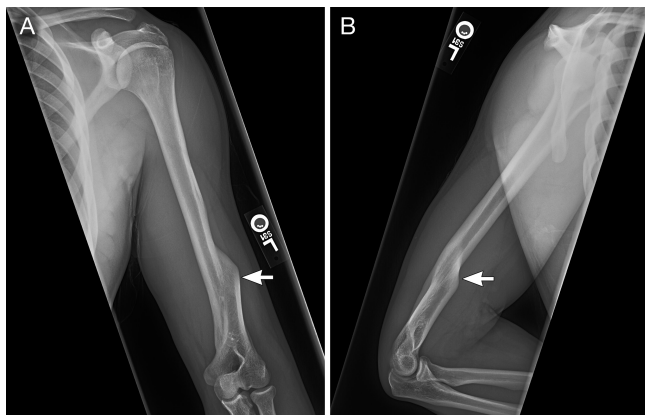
Anteroposterior (A) and lateral (B) radiographs demonstrate the malunion of the distal humerus (arrows).
